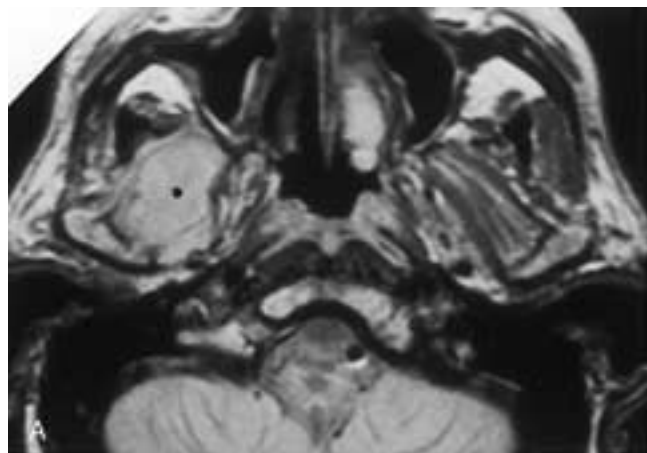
Masticator space abscess. Proton density (A) and T2-weighted MR (B) images demonstrate an abscess cavity centered within the right lateral pterygoid muscle (dots). The abscess cavity is hypointense on the T1-weighted image (A) and very hyperintense on the heavily T2-weighted image (B). Note that the cavity becomes isointense to the surrounding capsule on the proton density image (A). Coronal T1-weighted (C) MR image following the administration of contrast reveals thick enhancement of the abscess cavity (dots). The coronal image also demonstrates extension of edema above the zygomatic arch to involve the temporalis muscle (T) in the suprazygomatic masticator space.
